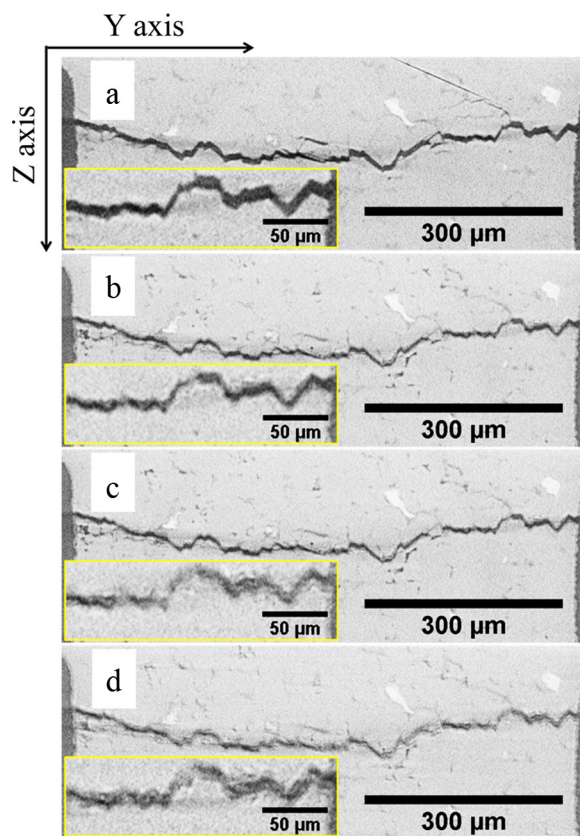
2D X-ray tomographic virtual cross-sections through the crack, grown in the X-direction at different stages of healing: (a) as-cracked; (b) after 4 h; (c) after 8 h; and (d) after 12 h exposure to 1200°C in air. Magnified regions of the crack are shown inset.
